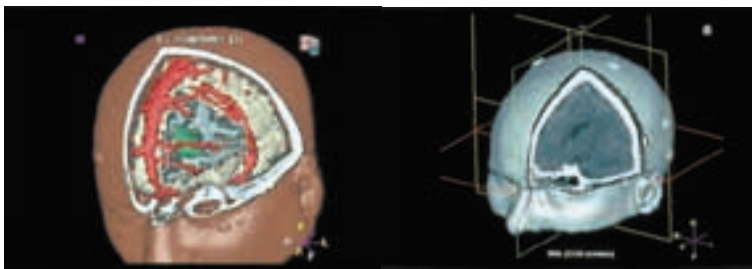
Advanced three-dimensional segmented views. a. Magnetic resonance images showing cutaway view of the brain with superimposed segmented outline of a frontal tumour (green) and the major cortical veins and dural venous sinuses (red). b. Computed tomography images with cut-away view of the brain. Such images may be created and infinitely manipulated in a short space of time and the anatomy inspected in great detail, allowing the surgeon a degree of preoperative planning unheard of until recently.
